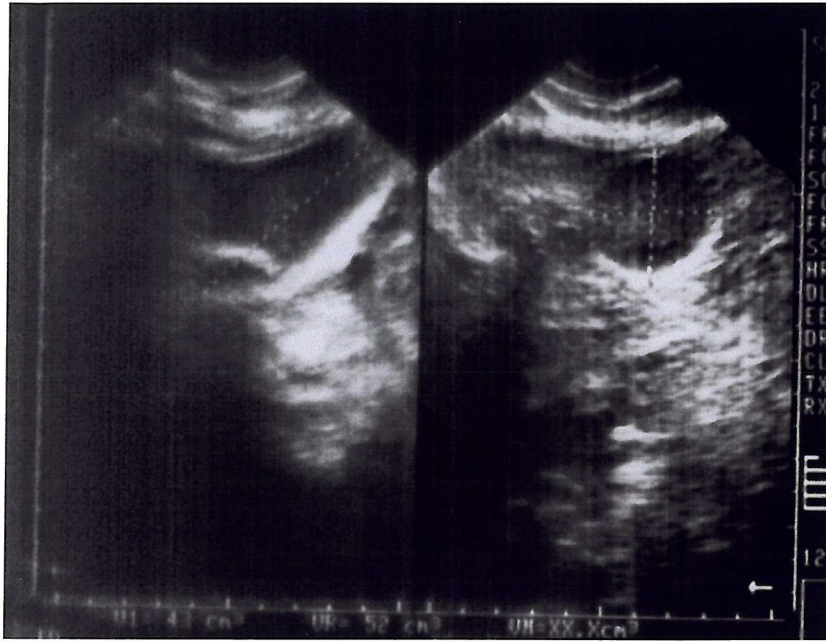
Sonographic estimation of gallbladder volume.
